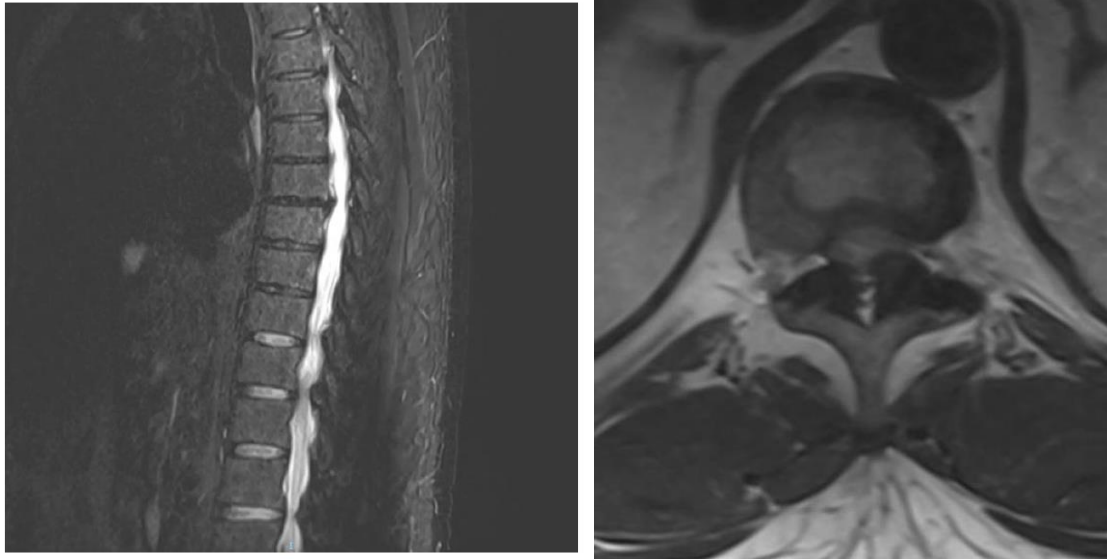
Thoracic-level MRI findings were consistent with the CT scan obtained earlier. T2-weighted sequence of MRI sagittal images showing hypointense signal in the posterior portion of the vertebral canal of T10-12. Axial views demonstrating spinal cord compression on the T10-T11 segment suggesting compressive myelopathy.
